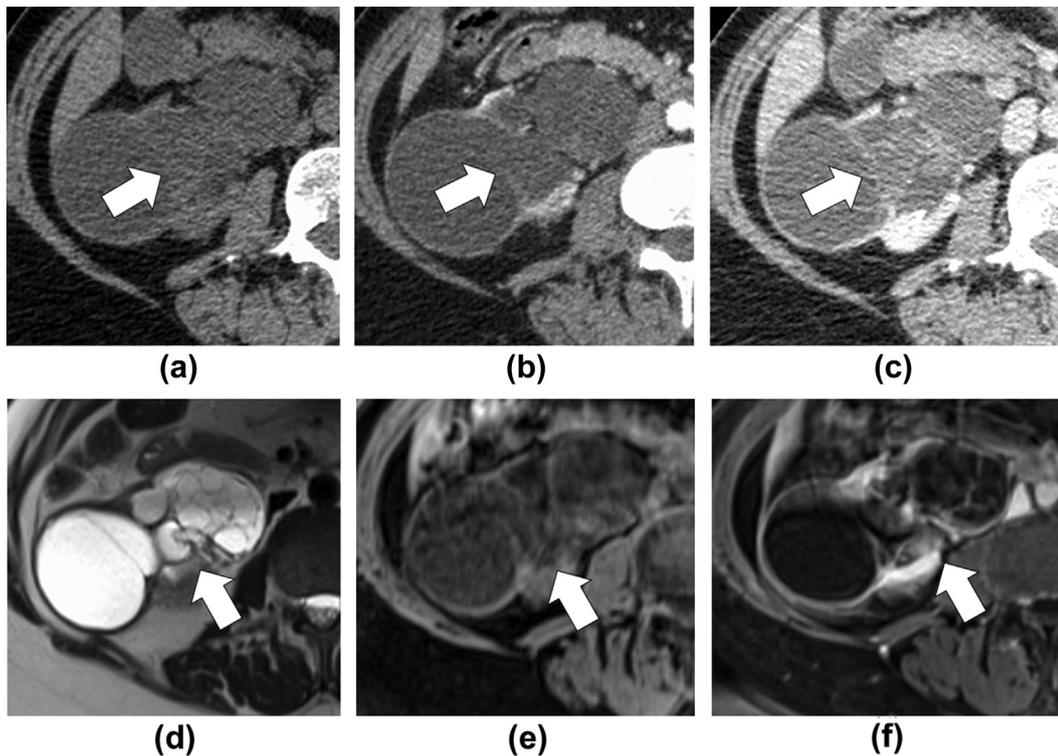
A 63-year-old woman with incidentally detected complex cystic right renal mass on ultrasound. Renal mass protocol CT was performed. (a) Axial unenhanced, (b) corticomedullary phase, and (c) nephrographic phase CT images show a complex renal mass with thick solid septa progressively enhancing components (white arrows). MRI was also performed in the same patient. (d) Axial T2-weighted ssFSE image shows a complex cystic mass in the right kidney (white arrow). Axial T1-weighted FS images before (e) and after (f) gadolinium injection shows septal and solid internal enhancement (arrows). A total nephrectomy was performed and final diagnosis was compatible with MEST.
